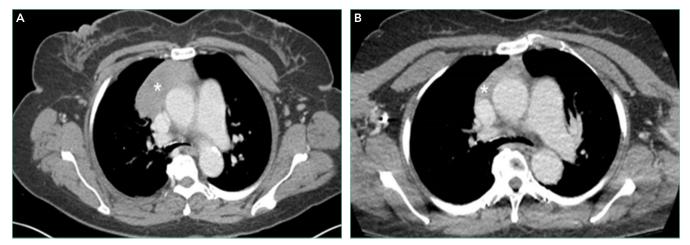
Chest CT with contrast showed a 3.9 × 8.0 × 7.0 cm anterior mediastinal mass (Panel A, asterixis), which shrunk to 1.7 × 6.5 × 5.2 cm after chemotherapy (Panel B, asterixis).
